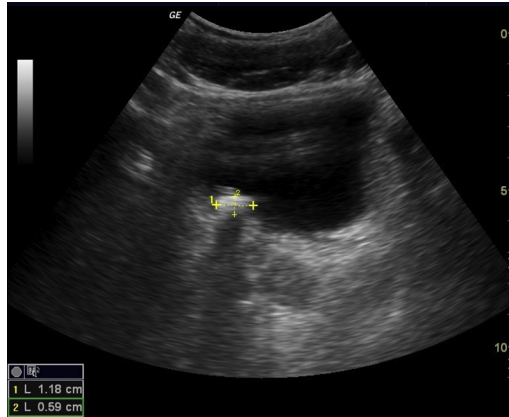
Bedside ED ultrasound showing a large distal ureterovesical junction stone. (Courtesy of Michael Stone, MD, Boston, MA.)
